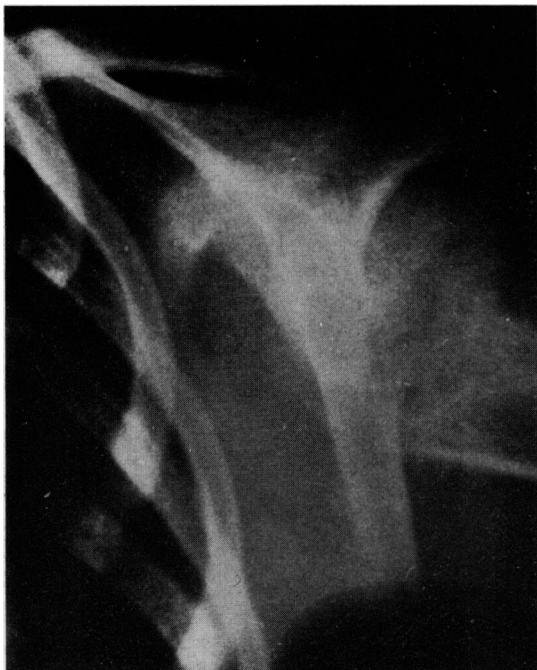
Case 6. X-ray of slipped upper humeral epiphysis of left shoulder. Extensive metaphyseal changes of humerus. Displacement of humeral shaft with dorso-lateral position of upper humeral epiphysis.
